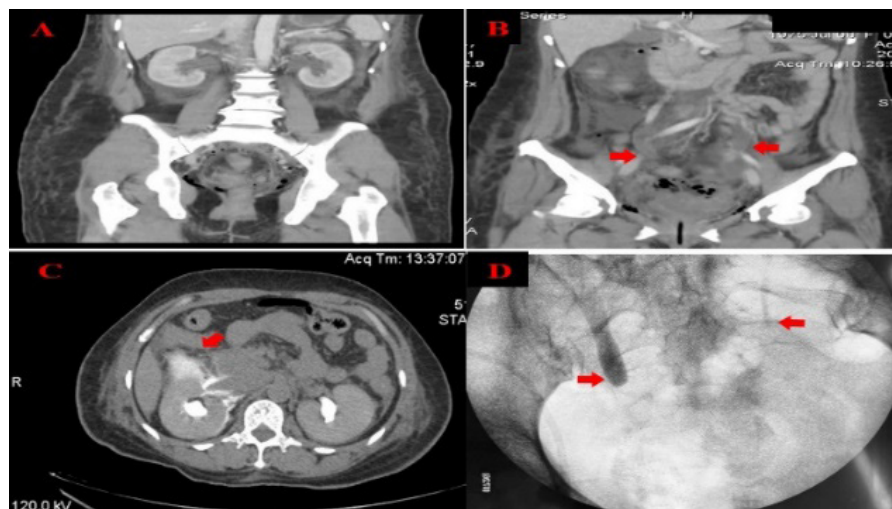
CT abdomen and pelvis with contrast showing: A: Bilateral hydronephrosis after hysterectomy, B: Bilateral distal ureteral stricture, C: Urinary leakage at right renal pelvis, D: Preoperative nephrostography showing bilateral distal stricture.
